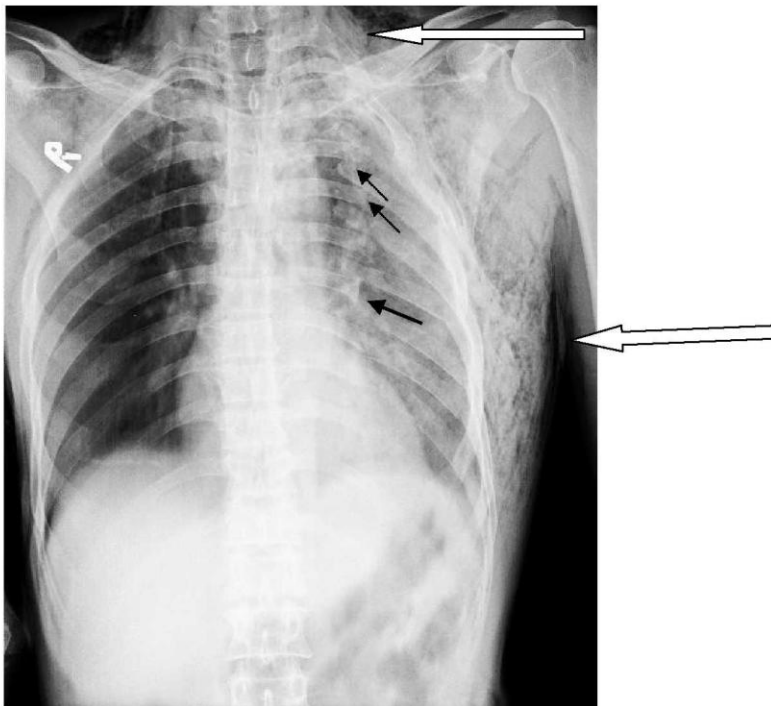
Frontal radiograph of the chest shows multiple rib fractures on the left side (black arrow marks). There is also extensive subcutaneous emphysema seen over left hemi-thorax and neck (white thick arrow marks).
